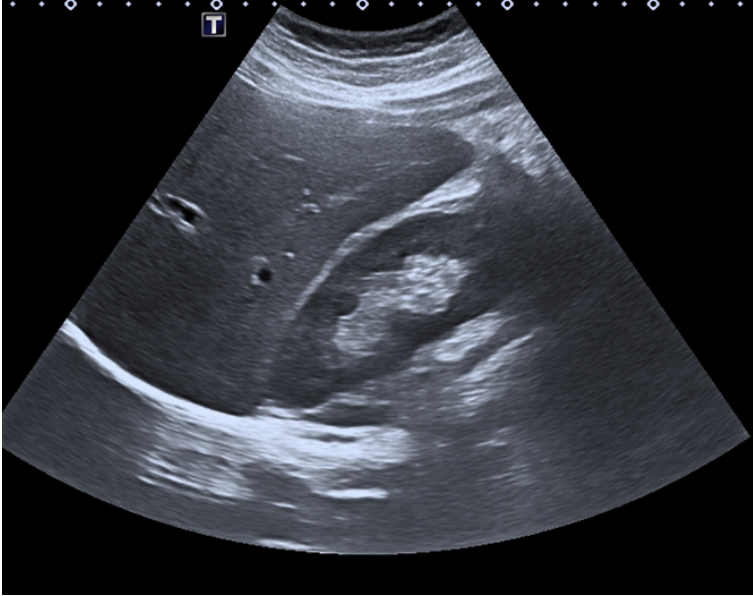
Abdominal ultrasound showing the right lobe of the liver and right kidney. [Ultrasound liver right lobe and right kidney](#) by Ptrump16 licensed under [CC BY-SA 4.0](#)
